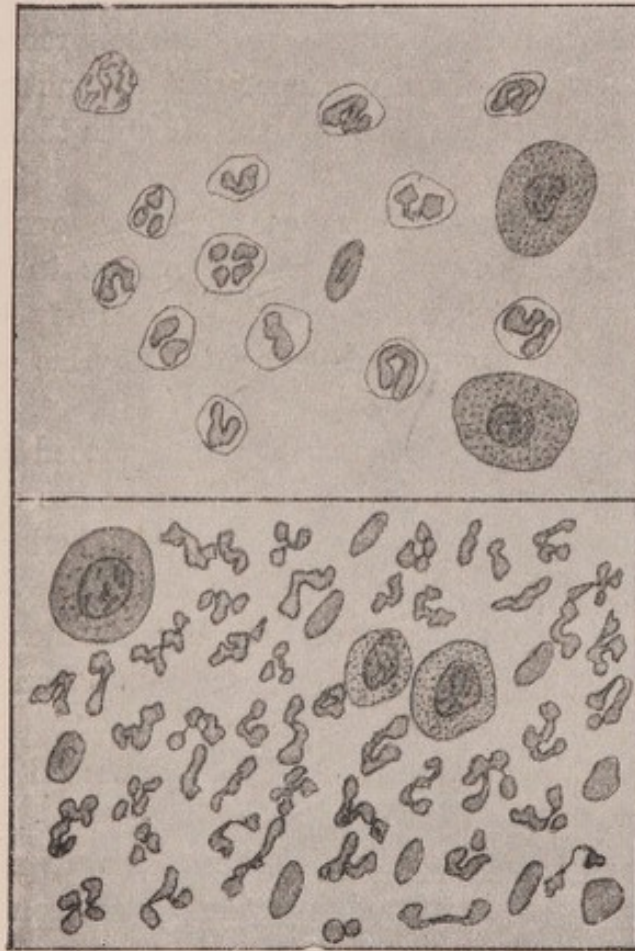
DISCHARGE OBTAINED ONE HOUR AND SIX HOURS RESPECTIVELY AFTER THE ELECTROLYTIC CLEANSING. (Roucaÿrol.)
